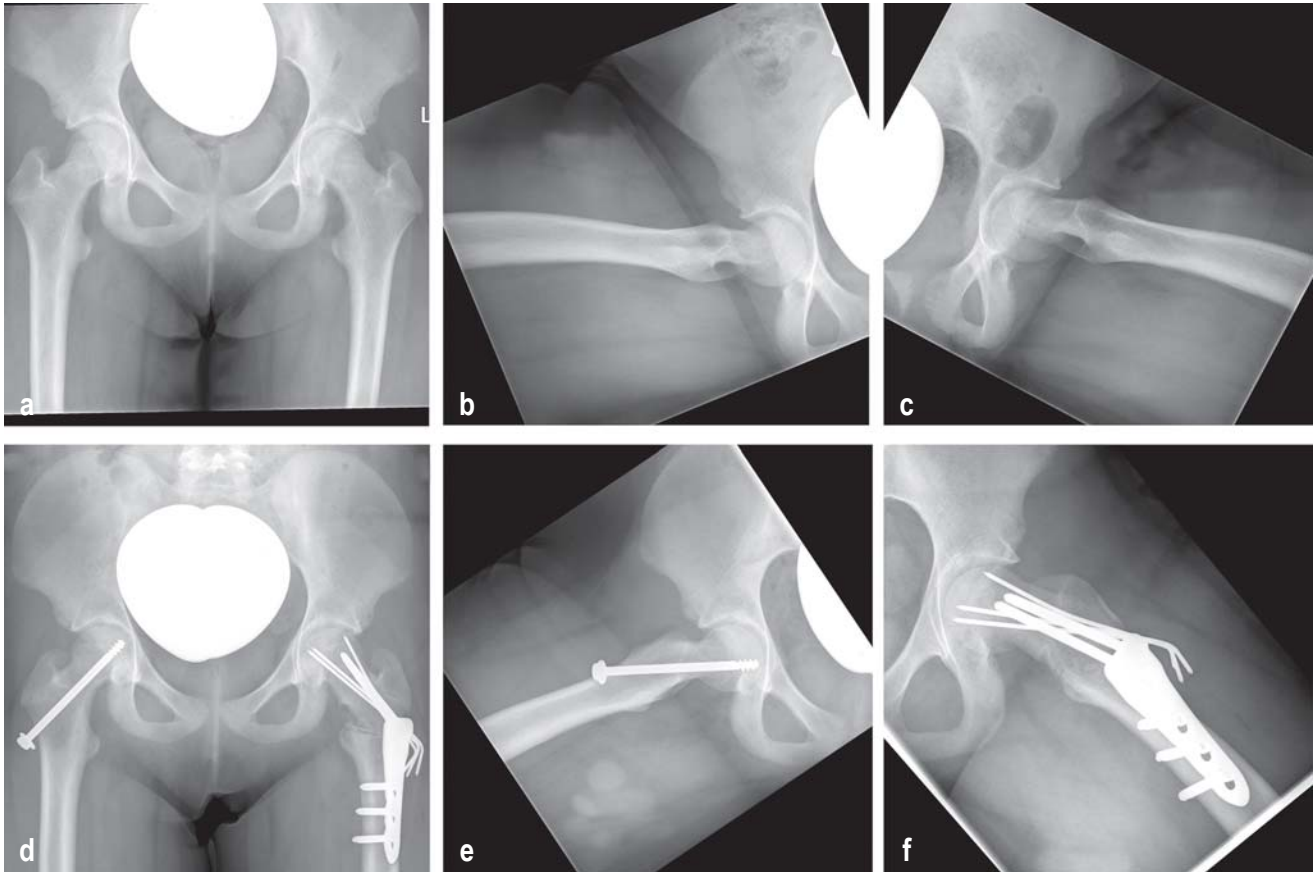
Radiographic diagnosis of slipped capital femoral epiphysis and its surgical management, showing the time course
